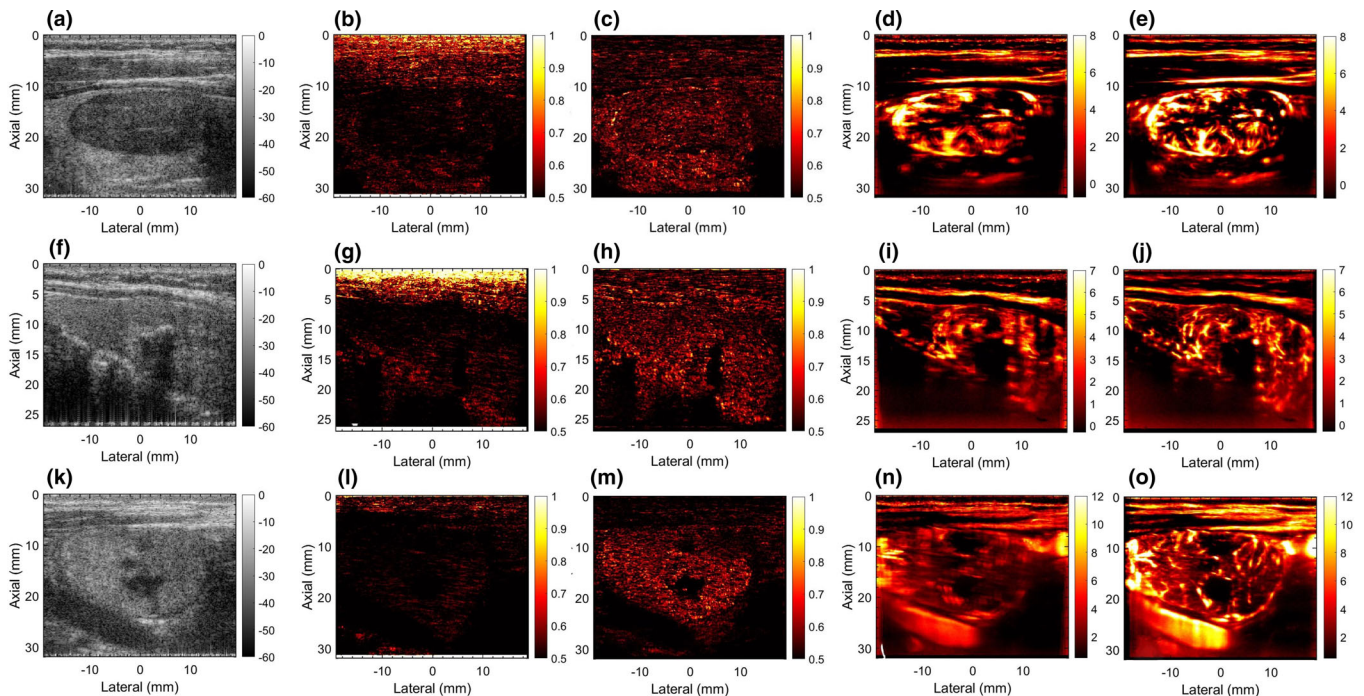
Rows 1–3 display five examples of thyroid microvascular blood flow (MBF) imaging, respectively. Column 1 displays the sonogram. Column 2 and 3 display the local spatiotemporal correlation images estimated without and with motion correction, respectively. Columns 4 and 5 display the MBF images estimated without and with motion correction, respectively. [Color figure can be viewed at wileyonlinelibrary.com]
